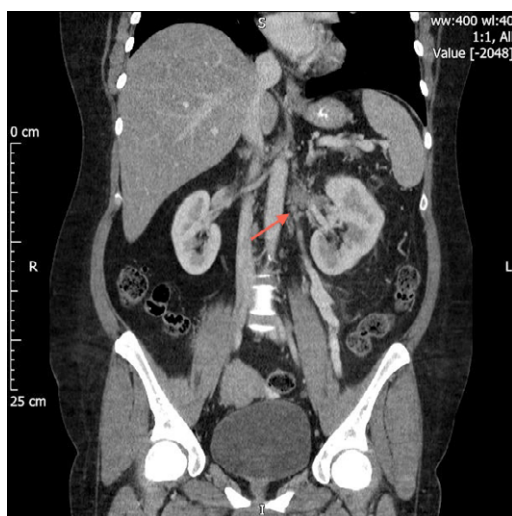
Coronal Section of CT abdomen and pelvis revealing thrombus within the left renal vein (indicated by the red arrow).
